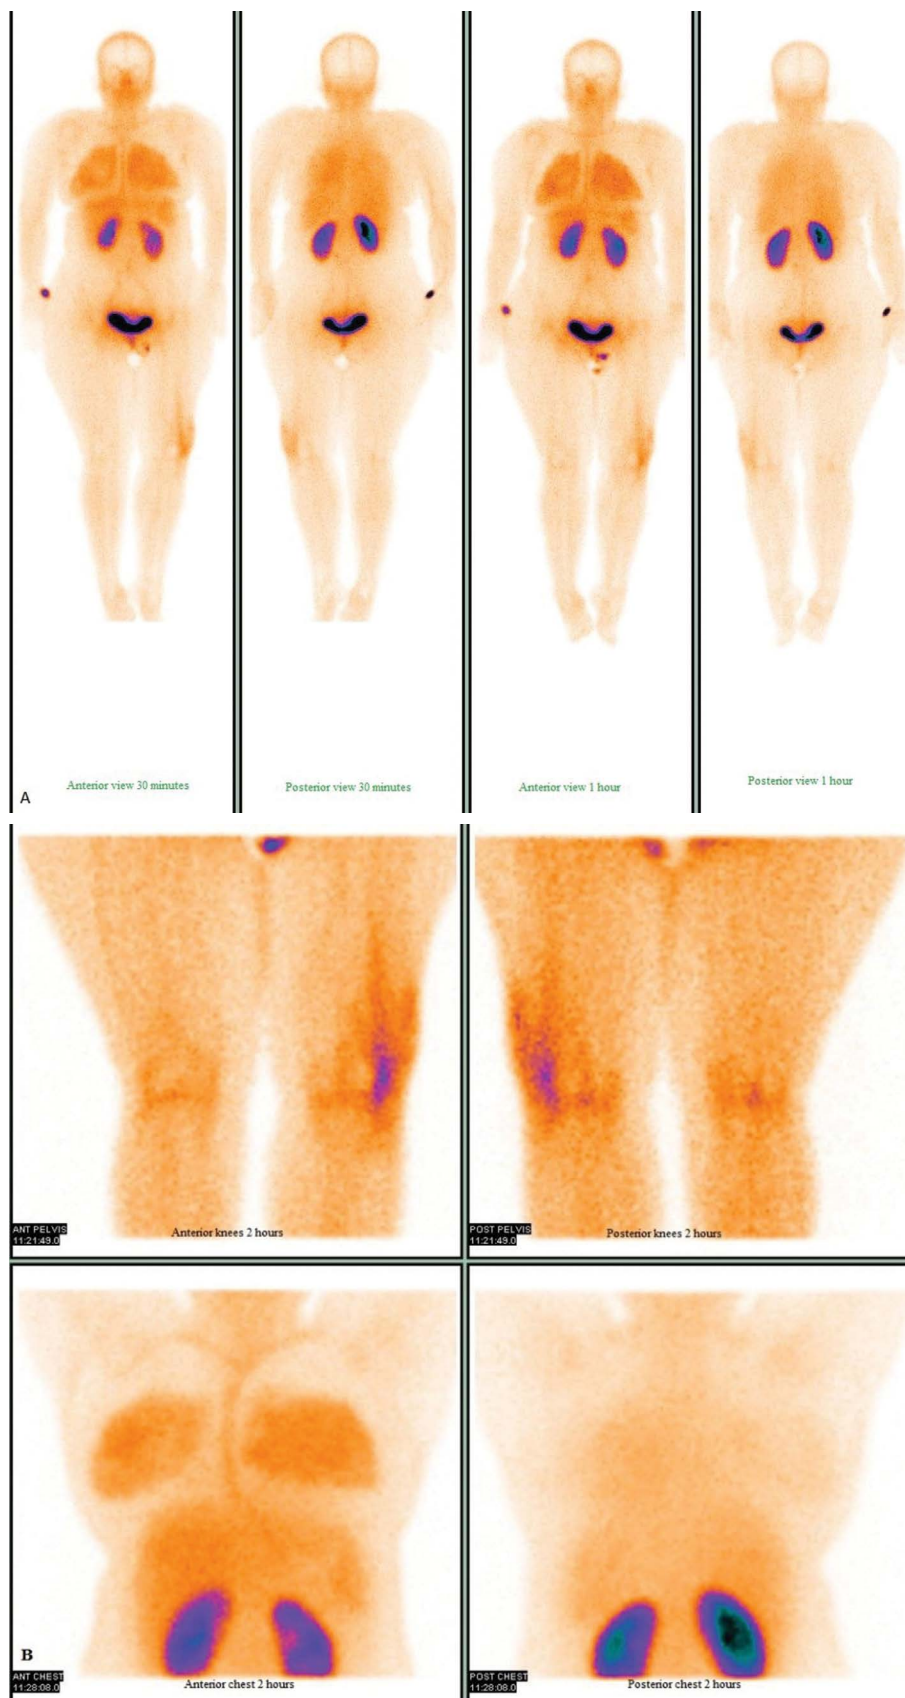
A. Whole-body planar images in anterior and posterior views (30 minutes and 1 hour) of UBI scintigraphy showed significant bilateral and diffuse lungs uptake (red arrows). Also mild soft tissue inflammation in the lateral aspect of the left lower thigh (blue arrow). B. Delayed 2 hours static images of chest and knees confirm the activity of lungs and lateral aspect of left lower thigh
